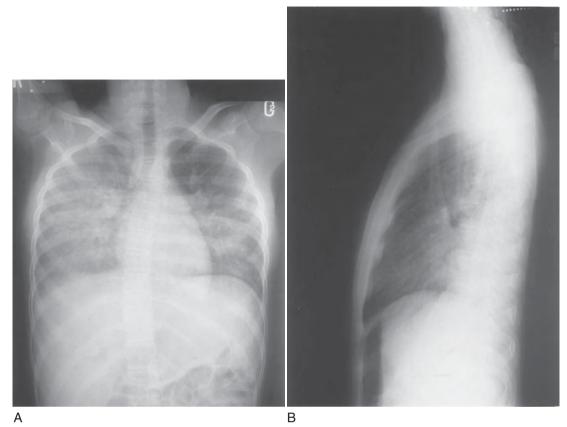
Posteroanterior (A) and lateral (B) chest radiographs of a 15-year-old patient with mental retardation and recurrent aspiration. The classic findings of dependent area consolidations in the lower lobes and posterior segment right upper lobe are demonstrated.
